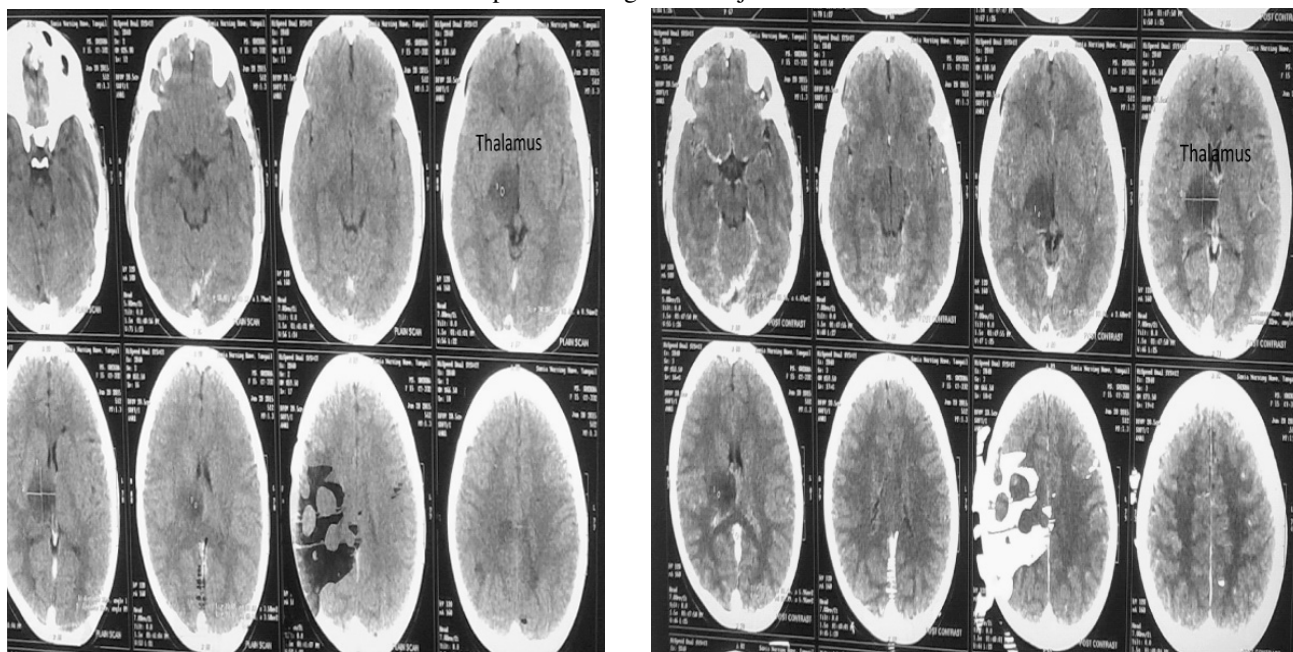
Pre- and post-contrast axial CT scan of brain showing mild-enhancing hypodense lesion in right thalamus
